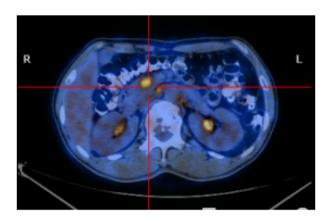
18F-fluorodeoxyglucose positron emission tomography-CT analysis. A whole-body 18F-fluorodeoxyglucose PET-CT scan revealed that the body and tail of the pancreas were slightly thickened and hypermetabolic, indicating a pancreatic malignant tumor. CT, computed tomography.
